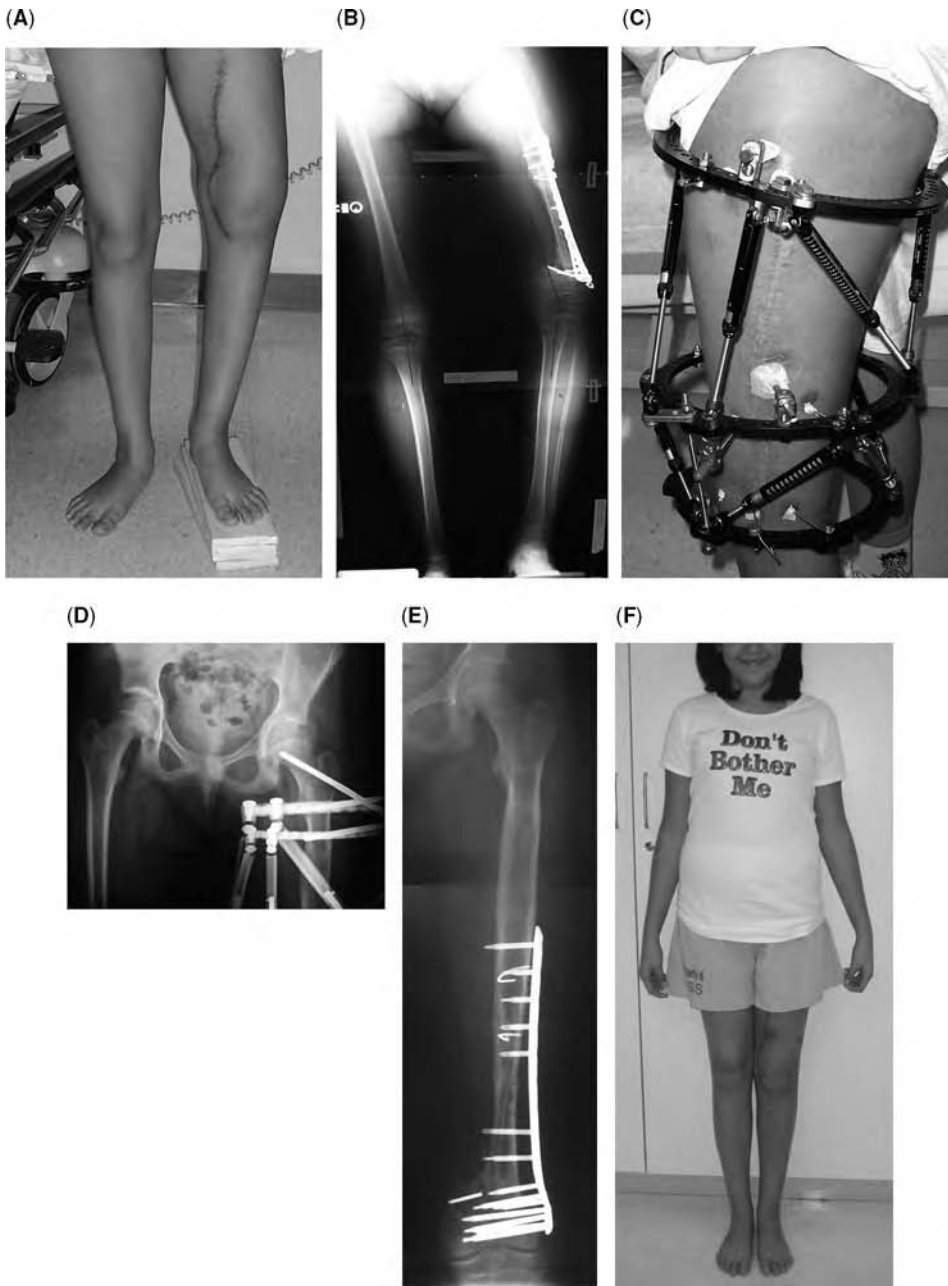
(A) This 11-year-old female underwent resection of distal femoral osteogenic sarcoma and reconstruction with a vascularized fibular graft and internal fixation. She has a mobile nonunion in 30° of varus with failed hardware and 7 cm of shortening. (B) This 51-in. erect, bipedal radiograph demonstrates persistent nonunion of the distal graft-host junction along with varus deformity and shortening. (C) The patient underwent Ilizarov reconstruction of the limb with a two level TSF. Lengthening was done at the proximal level and nonunion repair and correction of deformity was performed at the distal level. (D) Regenerate formation of 7 cm can be seen at the lengthening site in the proximal femoral diaphysis. A half pin was placed up the femoral neck to prevent a stress fracture in that area. (E) After frame removal, the patient sustained a fracture above the nonunion through the old free fibula graft. This was fixed with a percutaneously placed submuscular locking plate. (F) Six months after removal of external fixator, the patient is pain free and walking without support. The deformity and shortening have been corrected.
